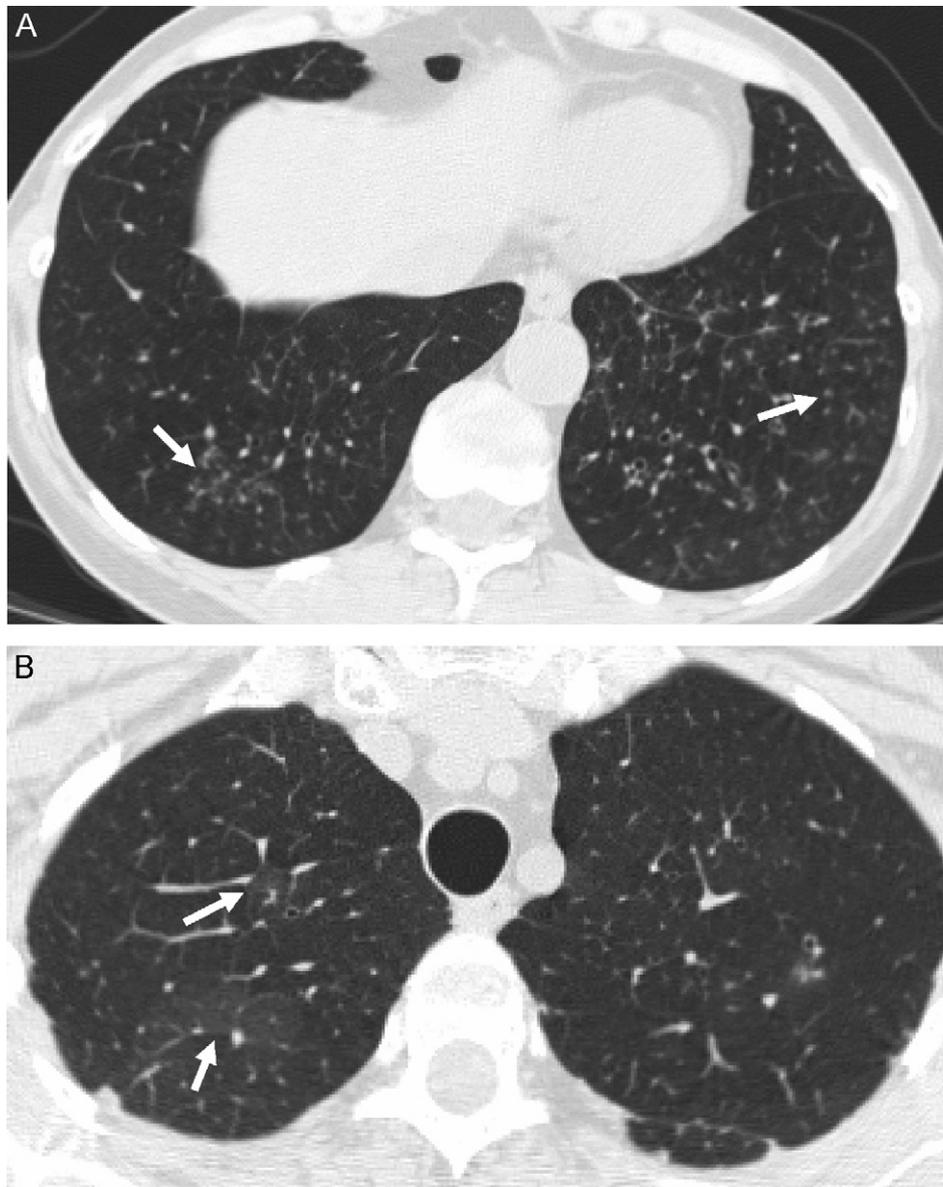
High-resolution CT of a 53-year-old woman with follicular bronchiolitis confirmed on surgical lung biopsy. (A) This image demonstrates numerous micronodules (arrows) suggestive of bronchiolar disease in both lower lobes. (B) Patchy ground-glass opacities (arrows) are seen in the apices, particularly on the right side.
